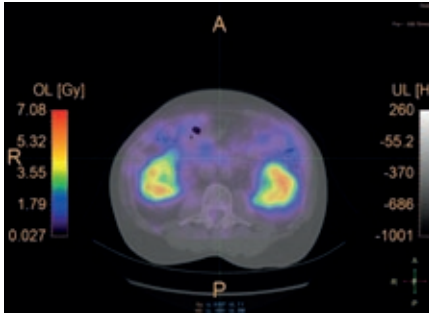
SPECT-CT dosimetry after ^{177}Lu -DOTATOC administration. critical organ activity (kidney) is often overlapped to intestinal activity.
